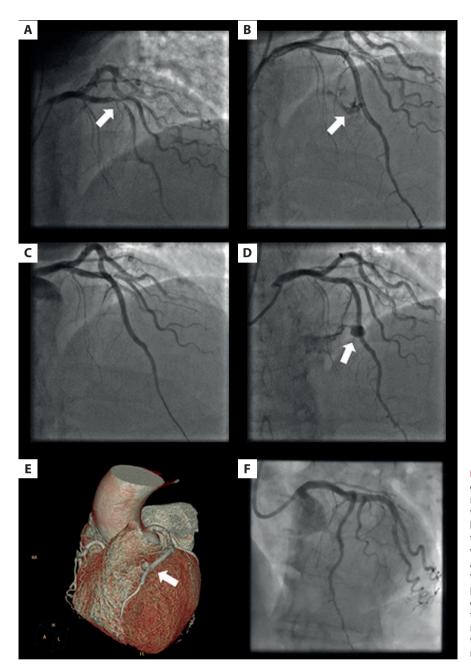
A. Coronary angiography: critical stenosis of the LAD in the medial segment on bifurcation with the first diagonal branch (arrow). B. Perforation with a fistula between the coronary artery and the cardiac ventricle (arrow). C. Perforation managed conservatively, final effect after the procedure. D. Epicardial coronary pseudoaneurysm with a fistula to the cardiac ventricle (arrow). E. Computed tomography: epicardial pseudoaneurysm with a canal communicating with the right ventricle (arrow). F. Spontaneous closure of the pseudoaneurysm
